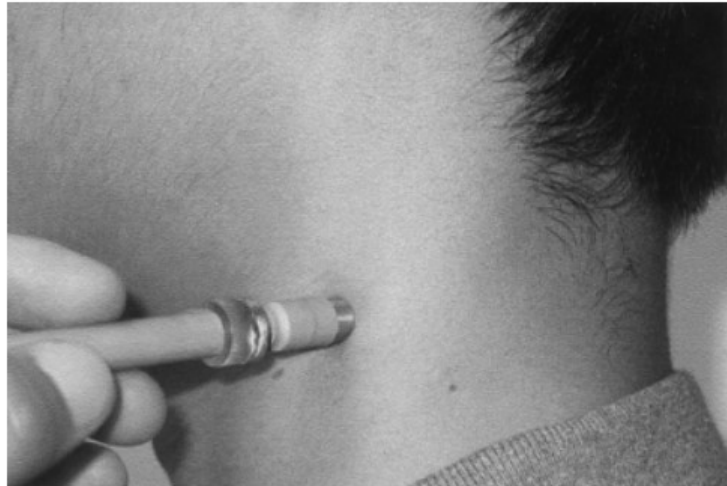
Tissue ultrasound palpation system measuring soft tissue stiffness on neck. The part that was touching the skin surface is the ultrasound transducer. The load cell was inserted in between the indenter and the pen-size holder. Figure was adopted from (Leung et al., 2002).
